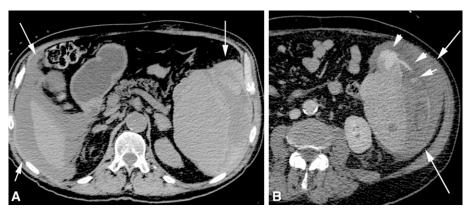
(A) Unenhanced axial computed tomography (CT), demonstrating spontaneous splenic rupture complicated by hemoperitoneum (arrows). (B) Axial contrast-enhanced CT obtained in the portal venous phase, showing active extravasation of intravascular contrast from the spleen (short arrows) and hemoperitoneum (long arrows).
